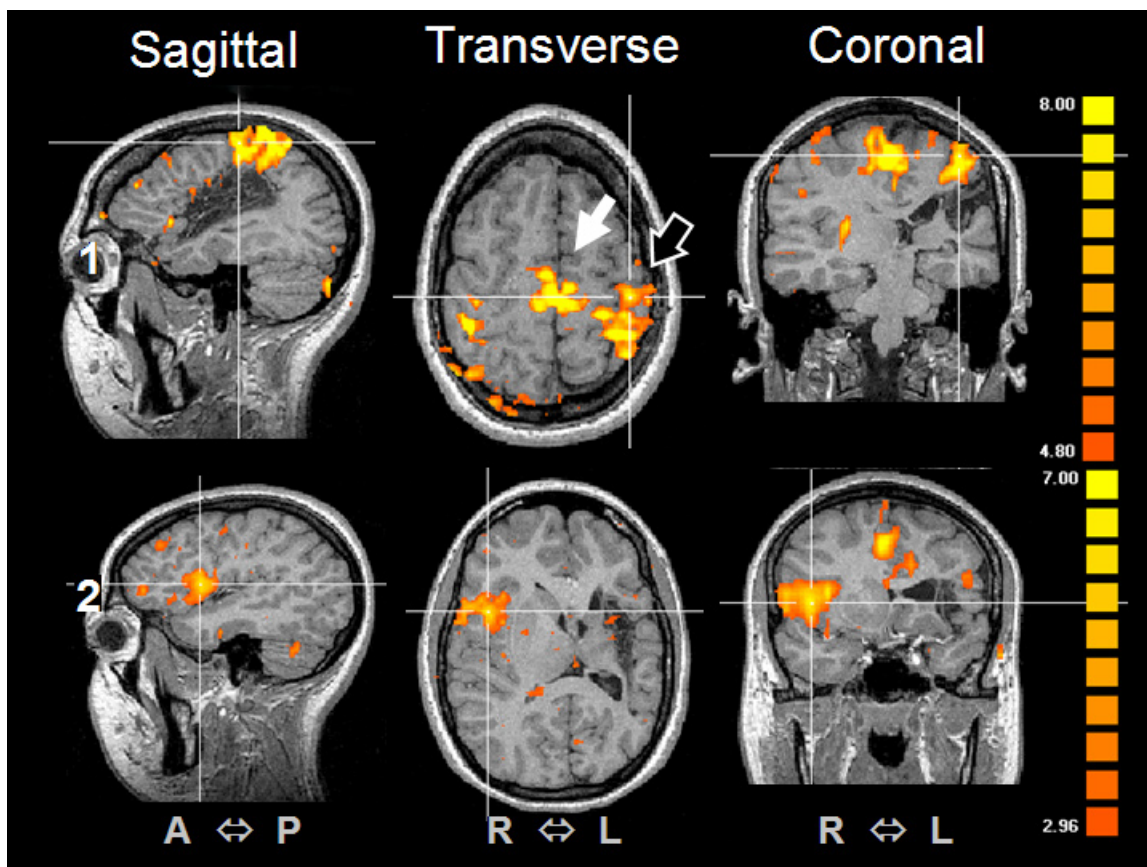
Functional MRI showing on the roll 1 a finger typing motor task with primary motor cortex (Brodmann area 4, Outlined White Arrow) and supplementary motor area activation (Brodmann area 6, Bold White Arrow). There is a tiny activation on the contralateral primary motor cortex, either. On the roll 2 one can see a robust activation on the homolog Broca area, on the right inferior frontal gyrus. Note the destructive lesion on the left frontal lobe.
